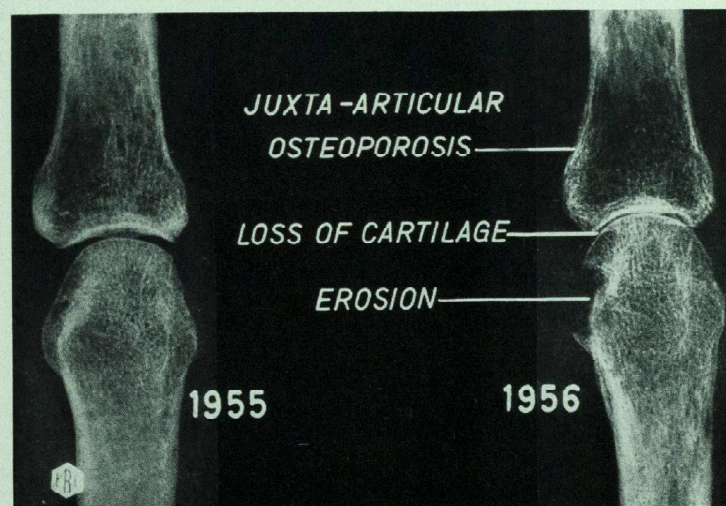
The X-Ray appearance of a rheumatoid joint.
